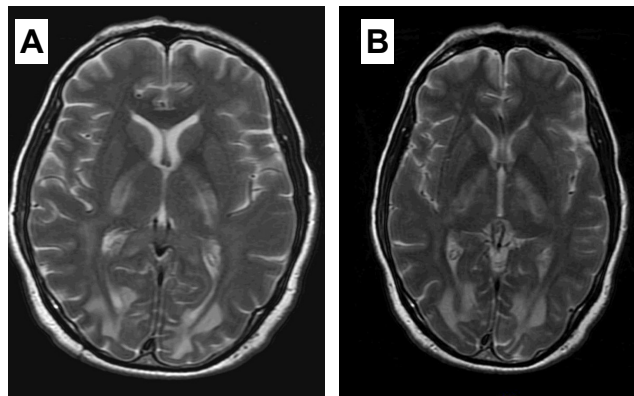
A & B: T2-weighted magnetic resonance imaging (MRI) of the brain (axial view) showing symmetric white matter hyperintensity, compatible with heroin-induced leukoencephalopathy.
